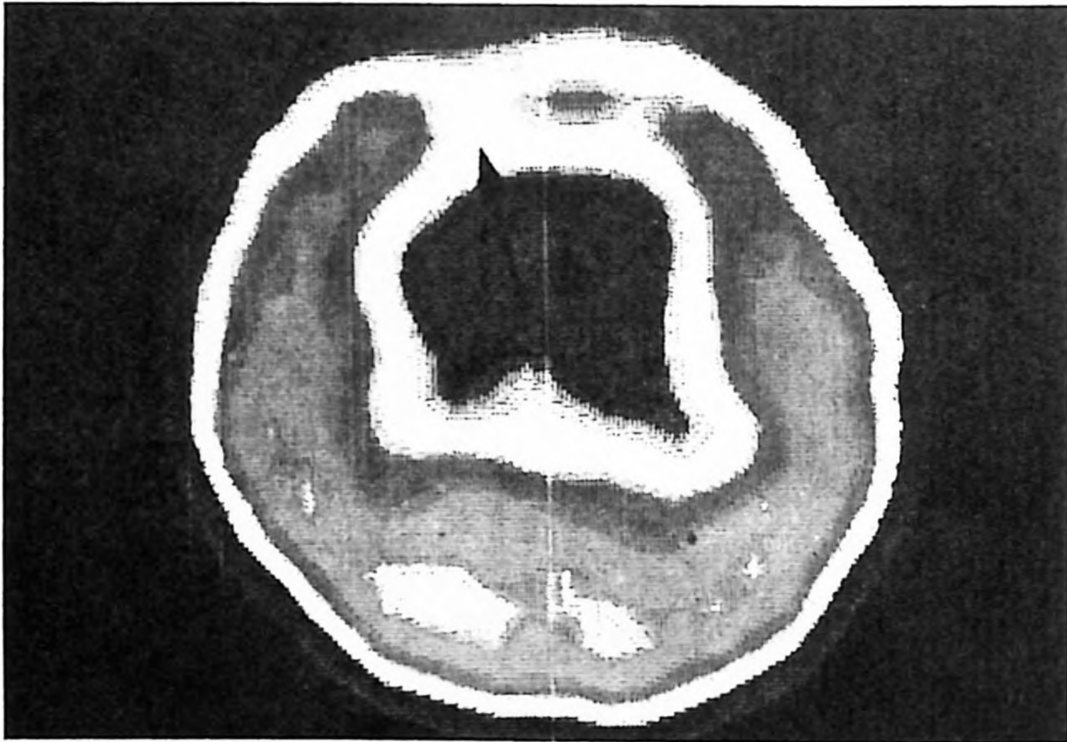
Interictal Tc99m-HMPAO-brain SPECT: Bilateral hypoperfusion of frontal areas.
